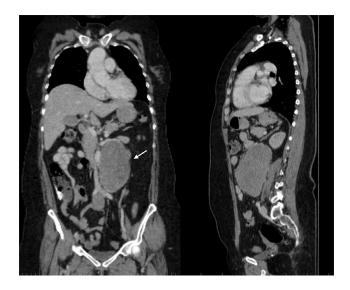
Coronal and sagittal contrast-enhanced CT chest, abdomen, and pelvis showed a retroperitoneal mass (note the arrow) located along the mid abdomen.
